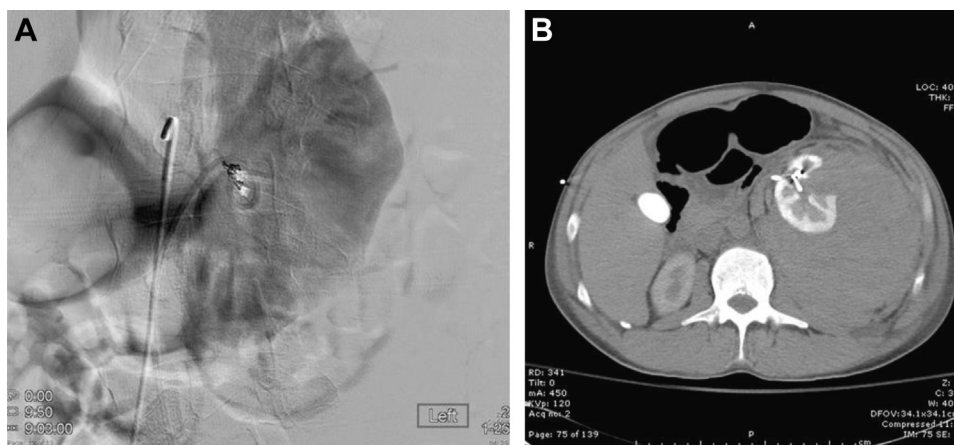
(A) Angiography (October 13, 2013) and second interventional radiology (IR) embolization. A second IR embolization was performed on the anterior segment of the left renal artery and interlobular artery using multiple 3-mm coils. The patient continued to bleed. (B) Computed tomography scan (October 13, 2013) showing an increase in retroperitoneal hematoma emerging from the left kidney.
